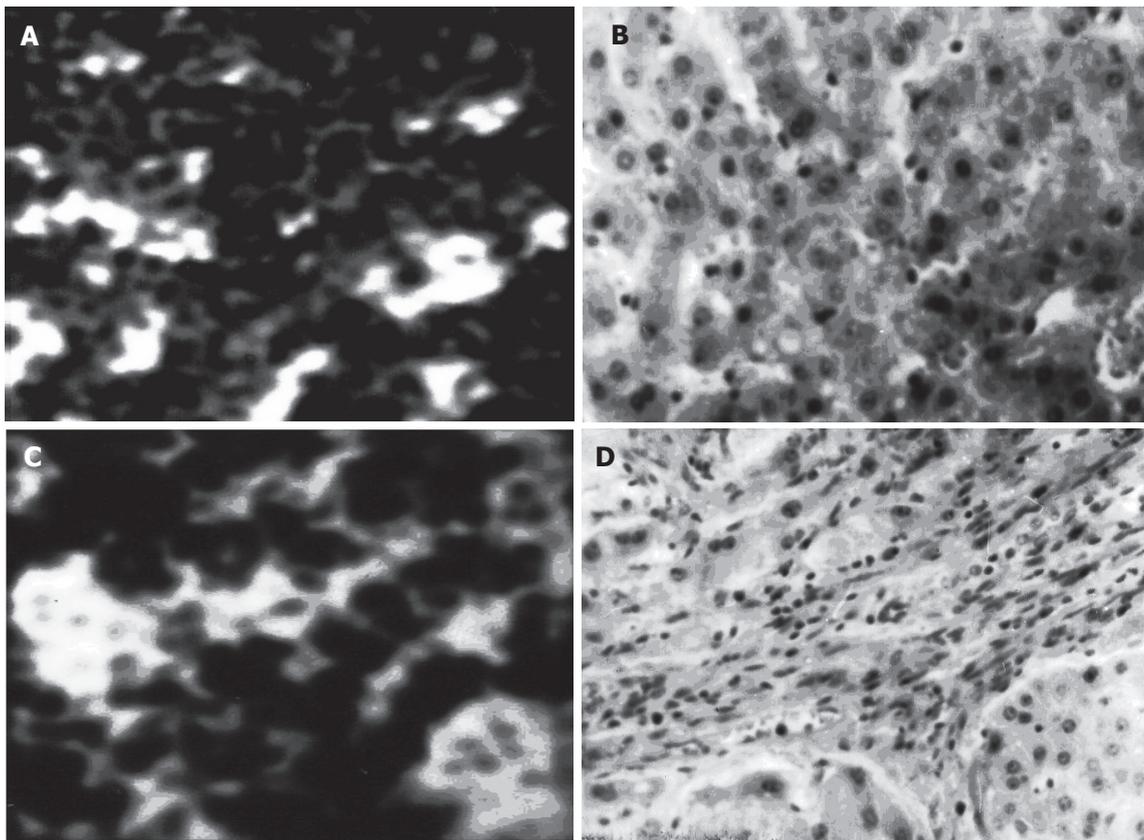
Ultrasound images of normal and cirrhotic liver and their corresponding pathological slices A: ultrasound imaging of normal liver; B: pathological slice of normal liver; C: ultrasound imaging of cirrhotic liver; D: pathological slice of cirrhotic liver.
